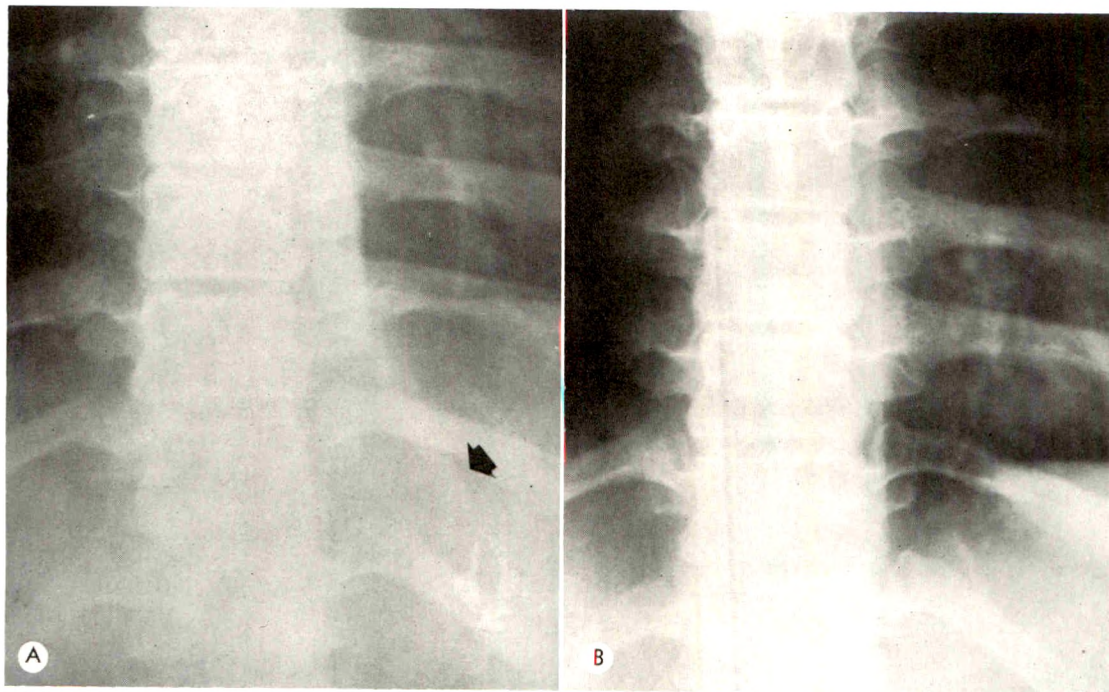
(A) A 19 year old girl with Hodgkin's disease complained of dorsal pain. Roentgenogram of the dorsal spine shows a long, fusiform, paraspinal mass on the left. The greatest displacement of the paraspinal line is at D11-12. She received 3,000 r incident dose to a posterior spine field in 18 days using cesium 137 radiation. (B) Roentgenogram of the dorsal spine made more than 3 years after treatment. The mass has disappeared. She was free of pain.
